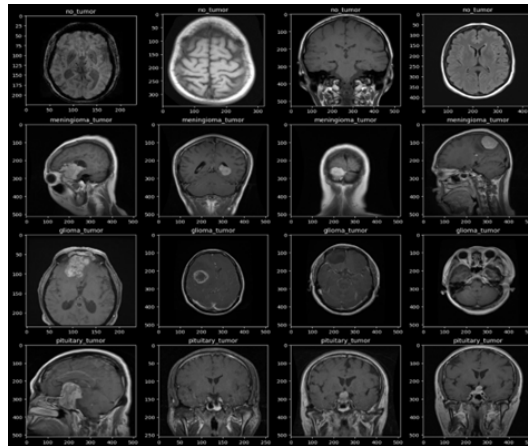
MRI data visualization Coursera dataset [36] classification results of tumor sample testing based on class.
